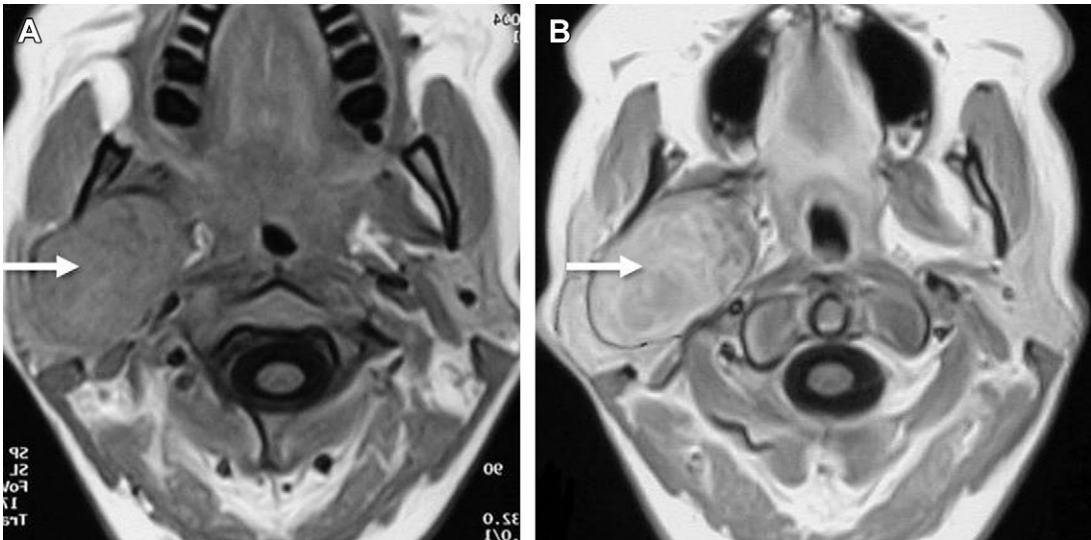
T3 acinic cell carcinoma. (A) Axial T1-weighted image shows a 5-cm well-demarcated right parotid mass (arrow). (B) Postcontrast T1-weighted image shows fairly homogeneous enhancement in this acinic cell carcinoma (arrow).
